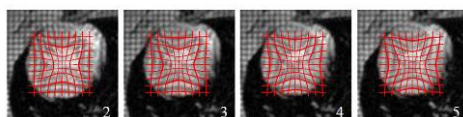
Deformed grid (red) superimposed on real tagged MRI data.
